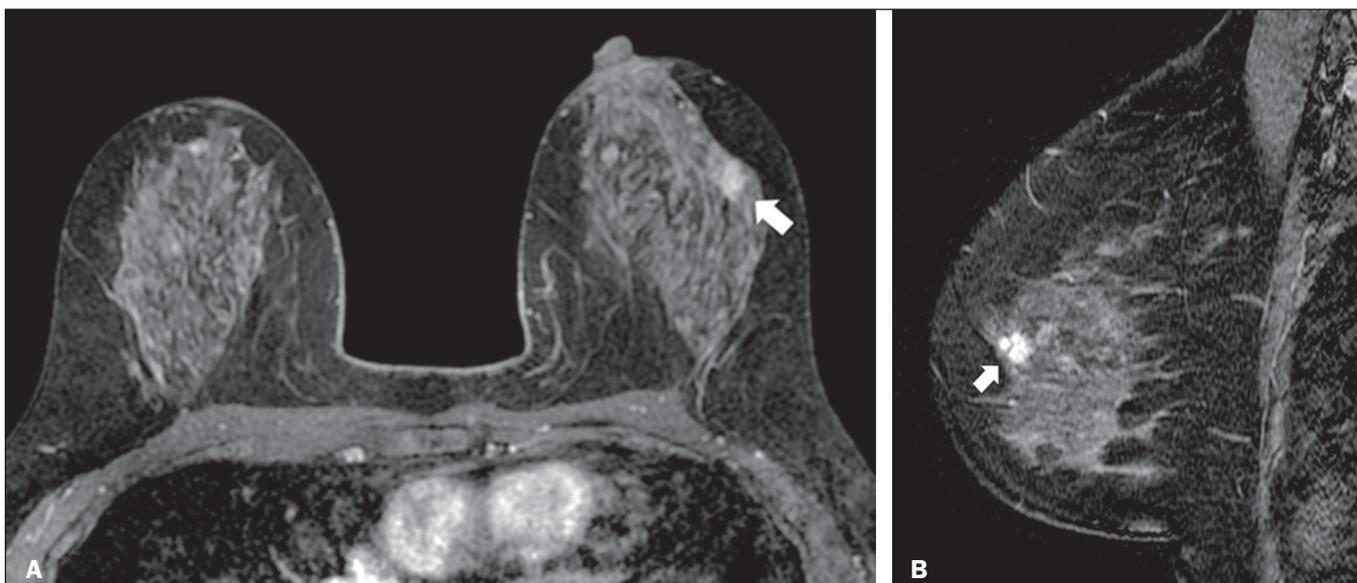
A 31-year-old female with a mass found in the right breast on ultrasound (not shown) was submitted do breast MRI. Axial and sagittal contrast-enhanced T1-weighted images (A and B, respectively) showing a round mass described as having “slightly irregular margins” (arrows) and classified as low suspicion—BI-RADS 4A. After ultrasound-guided core needle biopsy, the mass was diagnosed as a fibroadenoma.
